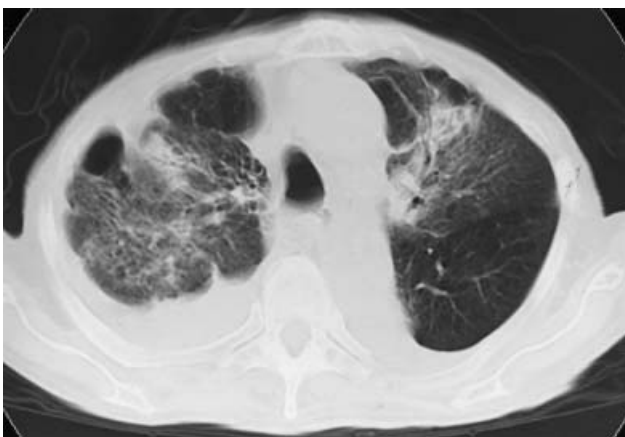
Computed tomography of chest shows reticulonodular pattern.
